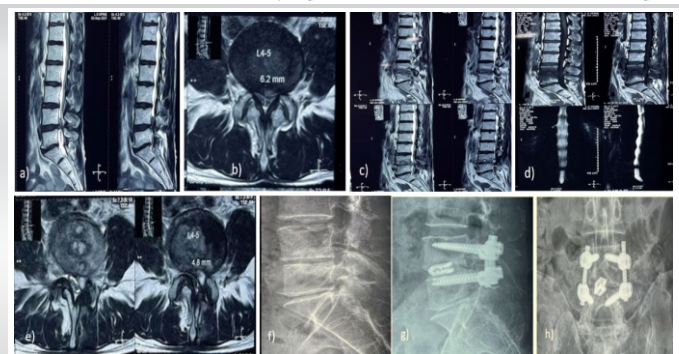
a-b) Preoperative MRI suggestive of disc herniation at L4-5. c-e) Postoperative MRI Sagittarius and axial view suggested spondylodiscitis with epidural pus collection at L4-5. f) Postoperative x-ray of lumbar spine lateral view suggested reduction in disc space with irregular endplates with sclerotic margins suggested infection and g-h) Shows postoperative x-ray of lumbar spine AP and lateral view of revision surgery shows TLIF at L4-5.
